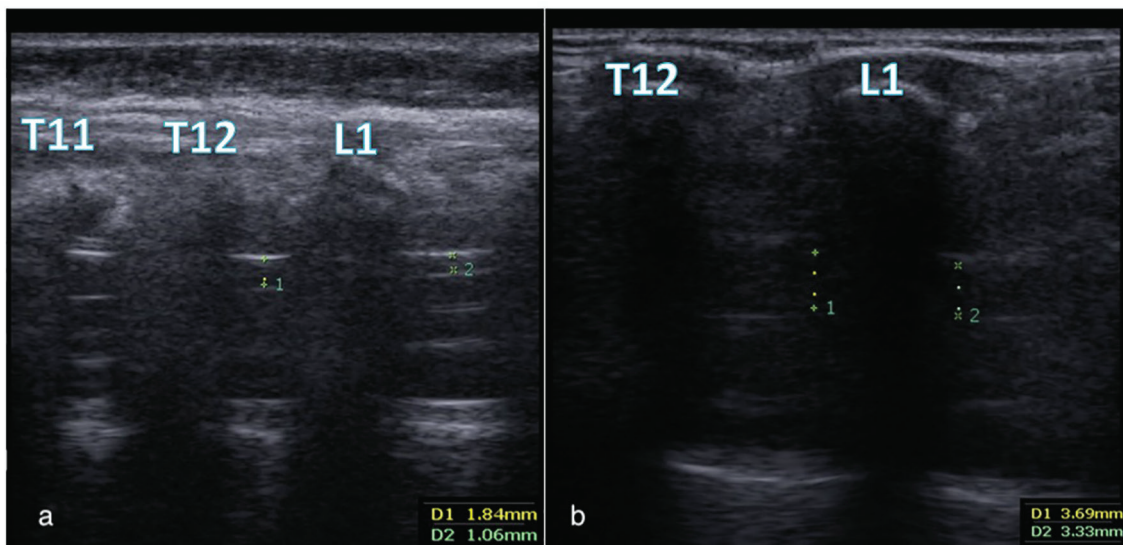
Ultrasound images show the maximum distance of the spinal cord from the posterior wall of the canal between T12 and L1 in a patient with tethered cord syndrome before (a) (1.84 mm) and after (b) (3.69 mm) the corrective surgery.
